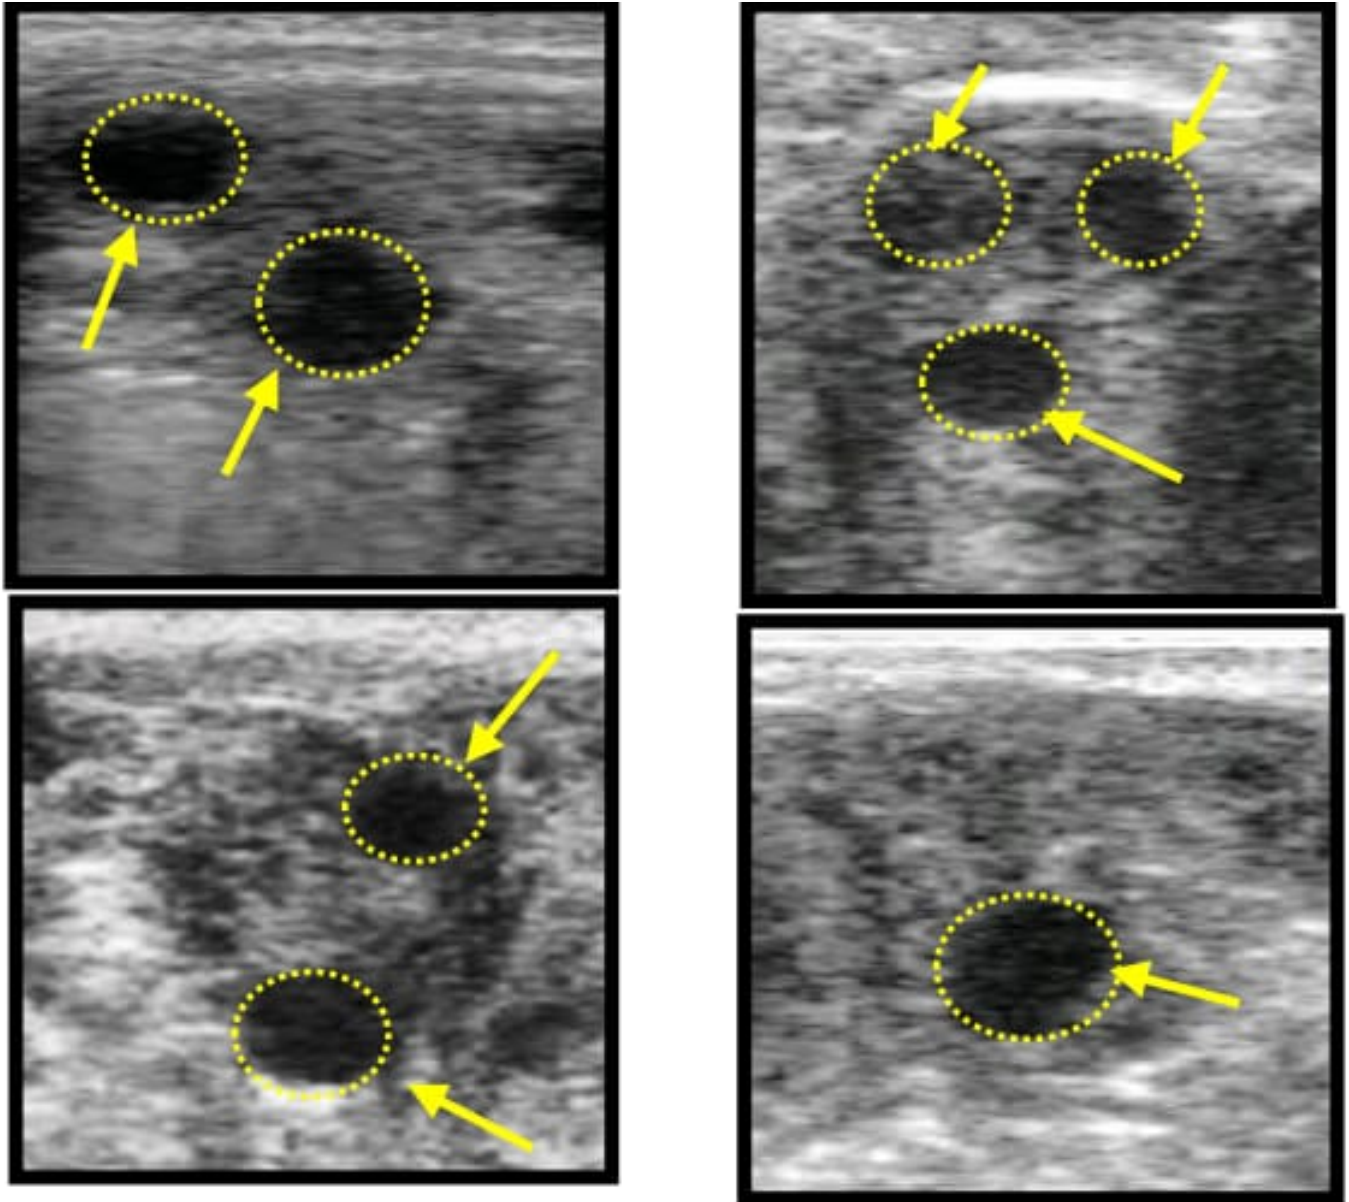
ultrasonographic images for preovulatory follicles (yellow arrows and dashed yellow circles) in letrozole treated Group
